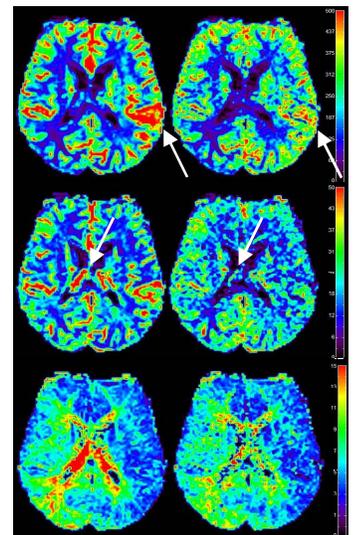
Hemodynamic parameter maps rCBF (first row), rCBV (second row) and rMTT (third row) for uncorrected (left column) and ICA corrected (right column) DSC-MRI data.
